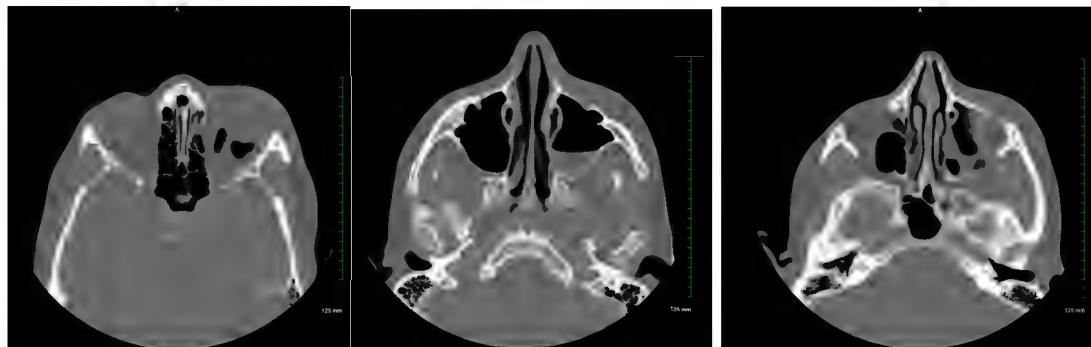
Non-contrast CT of the orbits. a Sagittal bone window shows fracture medial wall of the left orbit with intraconal gas. b Sagittal bone window shows layering hemorrhage in the left maxillary sinus c changes to the inferior rectus as it passes over the fractured fragment of the orbital floor.
